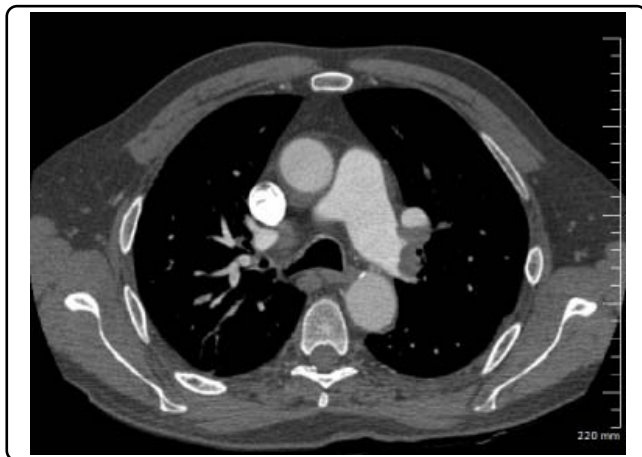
CT axial scan taken after treatment shows the left pulmonary artery, there is a hipodense image that causes 90% of obstruction.
